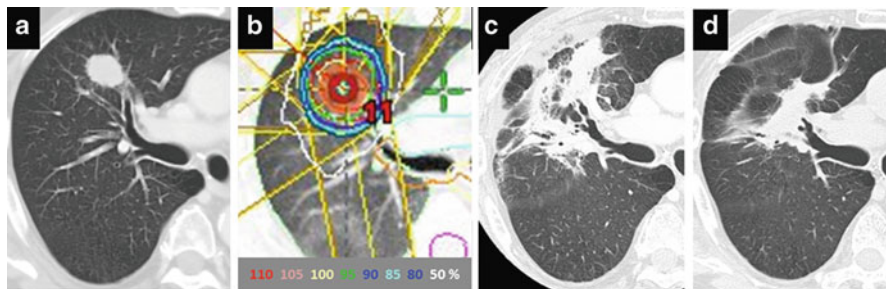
Post-SBRT radiation fibrosis considered modified conventional pattern. (a) CT image before SBRT, (b) Isodose distribution prescribed with 48 Gy in 4 fractions at isocenter, (c) CT image at 5 months after SBRT, (d) CT image at 24 months after SBRT
